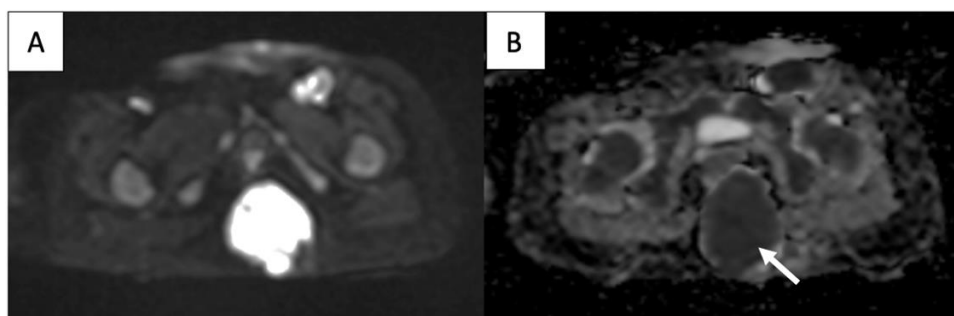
Initial MRI: Axial diffusion-weighted image (A) and corresponding ADC map (B) demonstrating marked restricted diffusion (low ADC, arrow) within the solid components, indicating high cellularity.
